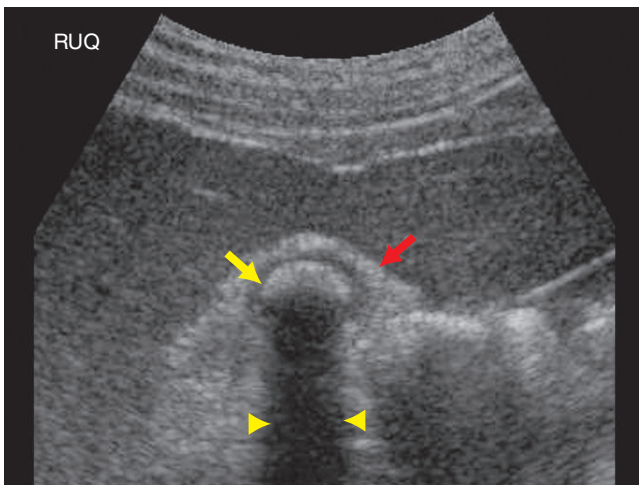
Real-time ultrasound of right upper quadrant of the abdomen demonstrates slight gallbladder wall thickening (arrow) noted anteriorly. Next there is an echogenicity (arrow), then an acoustic shadow (arrowheads). These three are the components of wall (W), echo (E), and shadow (S).
